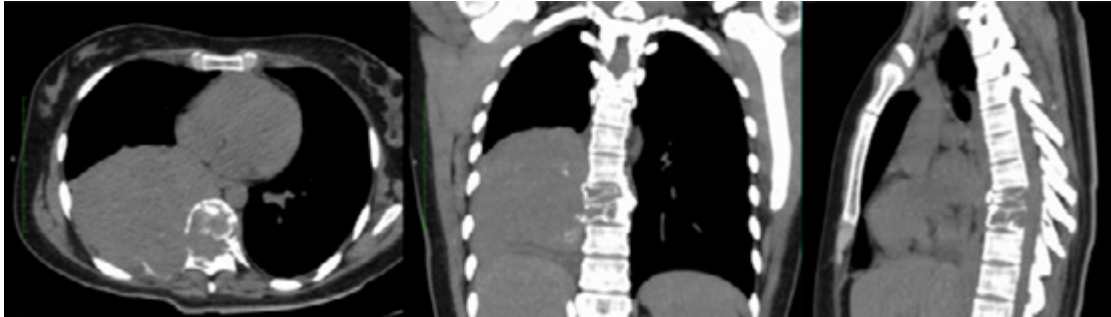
High resolution computed tomography (CT) of the thorax in axial, coronal and sagittal planes.
